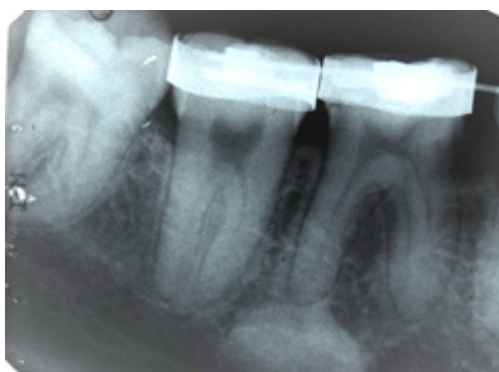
Case 1: Periapical radiograph (PA) of LR6 during space closure
